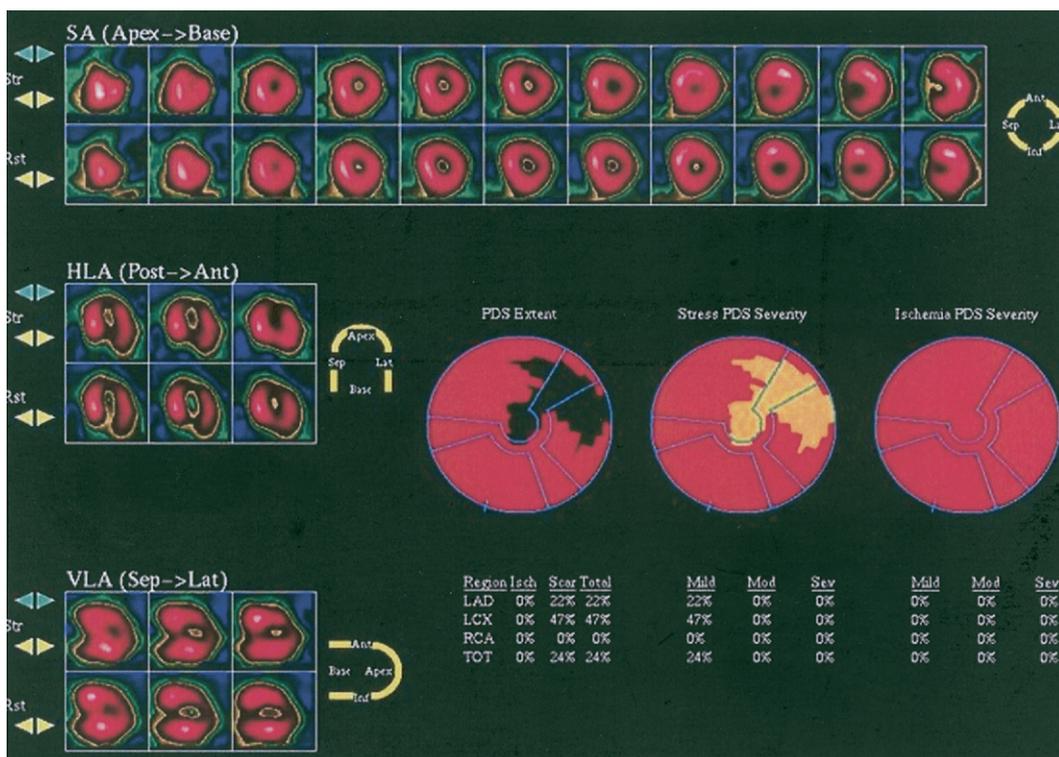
Single-photon emission computed tomography perfusion imaging from a hypertrophic cardiomyopathy patient. Septal thickness is increased as is the count activity (hot spot) in the septum relative to lateral wall. The computer analysis software registered a fixed perfusion defect (scar) in the lateral and apical regions upon normalization to the septum. HLA = horizontal long axis; PDS = perfusion defect size; SA = short axis; VLA = vertical long axis.
